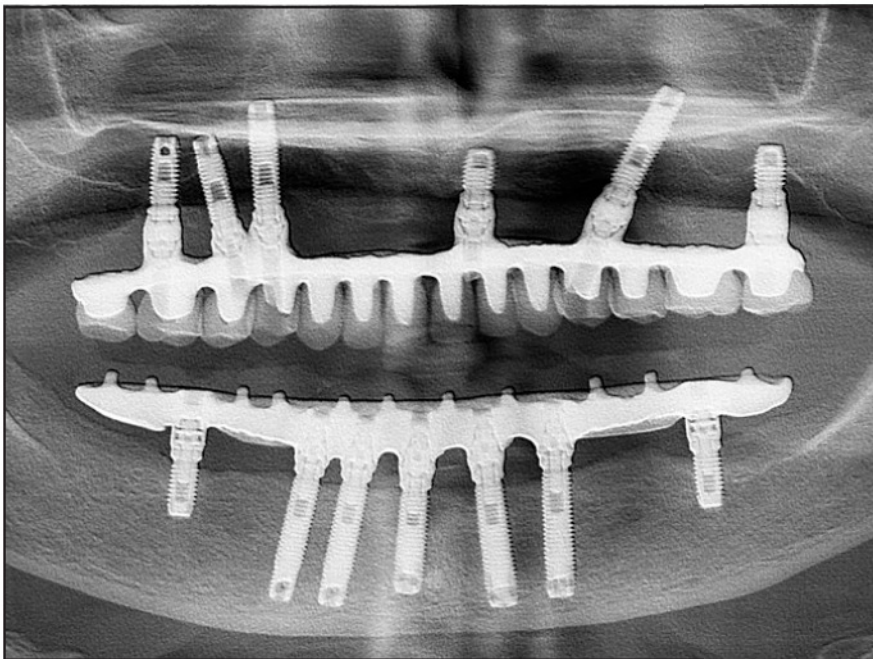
Latest panoramic radiograph shows stability of the bone level around dental implants.
